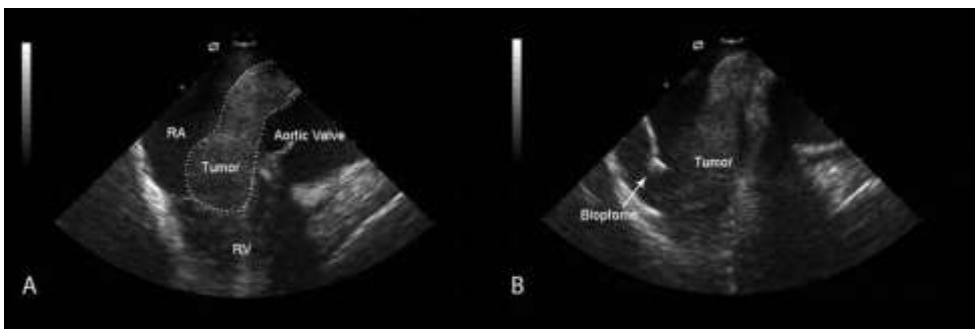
Panel A: An intracardiac mass originating from the superior vena cava is extending into the right atrium (RA) and tricuspid valve. (RV = right ventricle). Panel B: Intracardiac echocardiography is used to monitor and guide the biopsy by visualizing both tumor and biopptome.
